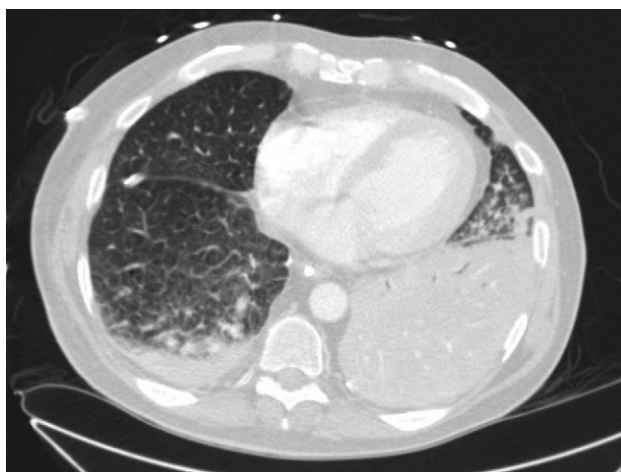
CT chest: interval development of a dense consolidation of nearly the entire left lower lobe
